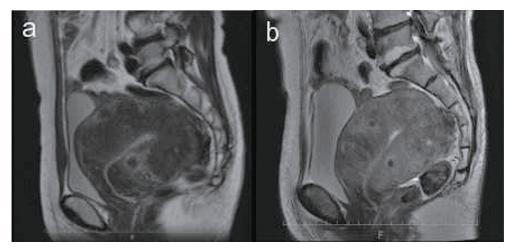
(a) Magnetic resonance imaging (MRI; T2-weighted image) in the sagittal view when the patient was initially referred to the institute; diffusely thickened myometrium with low signal intensity indicates the presence of adenomyosis. (b) MRI under the same condition when the patient was diagnosed with endometrial cancer. Although uterus size does not show considerable change, the signal intensity in (b) appears higher than that in (a).
